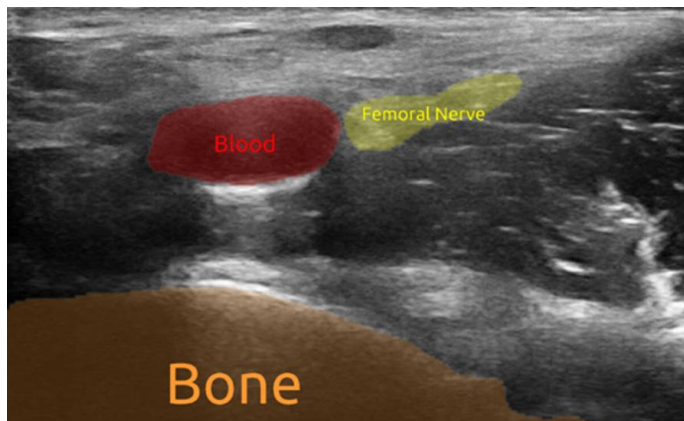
Example of an ultrasound femoral image segmented and visualized in real-time with FAST. This figure was cited from [57].
